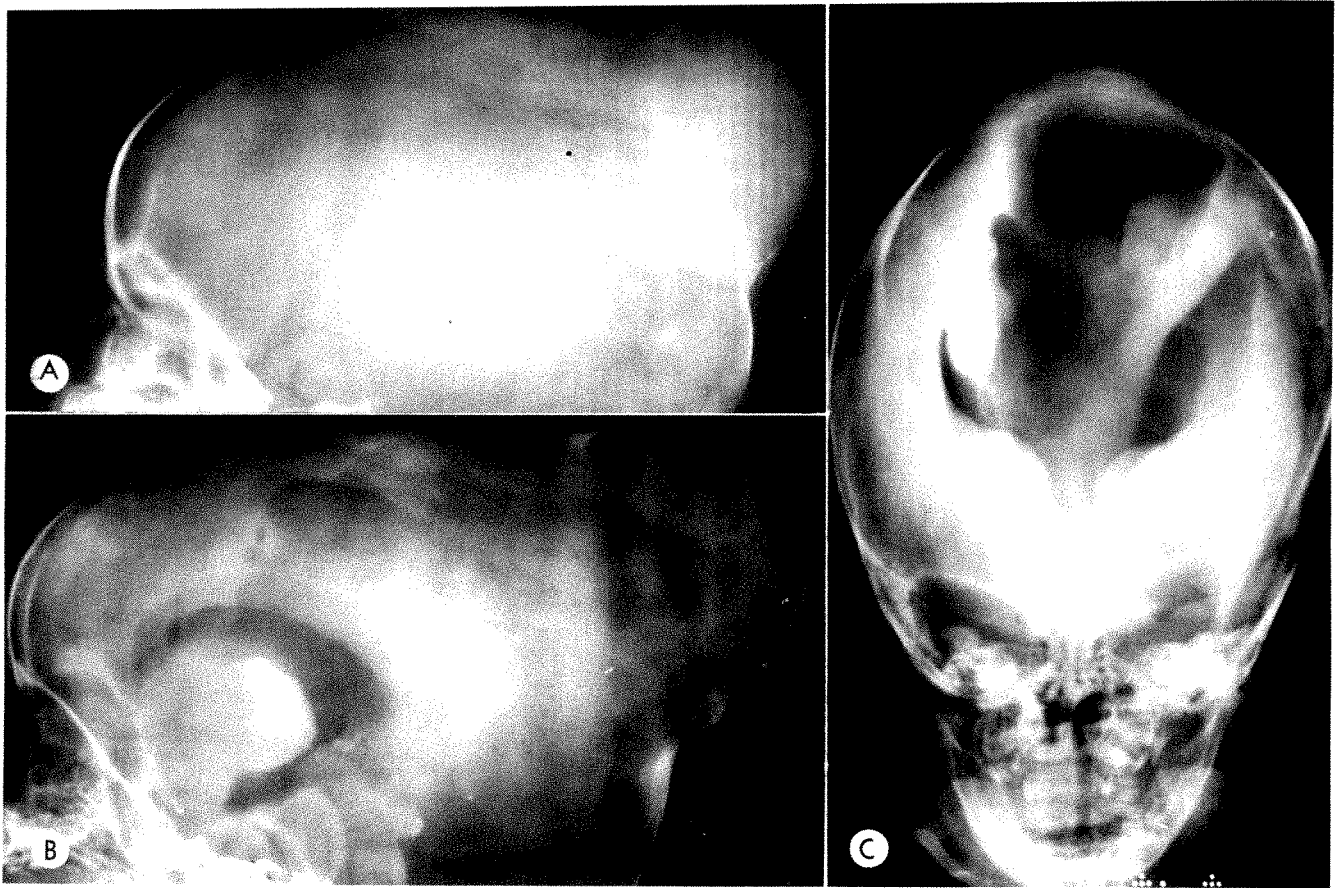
Large soft tissue mass in posterior interparietal region due to herniation of third ventricle (dorsal or diencephalic cyst) in newborn with absence of corpus callosum. A, Lateral skull roentgenogram. B and C, Ventriculogram, anterior and frontal projections. (Courtesy of F. N. Silverman)
